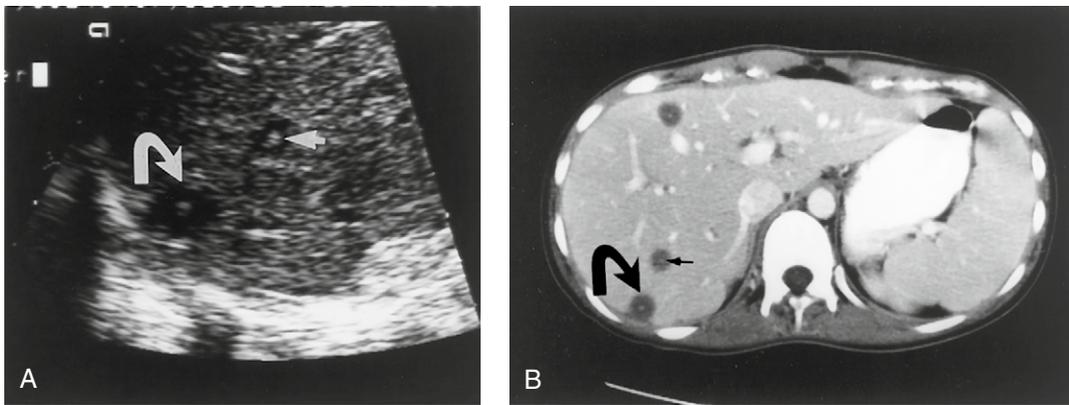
Aspergillus* liver abscesses in a young woman with leukemia who presented with abnormal liver function tests and fever. (A) Abdominal sonogram transverse scan through the liver shows hypoechoic areas (curved arrow) with a central echogenic focus (small arrow). (B) CT image of the liver in the same patient shows multiple hypodensities (curved arrow) with central hyperdensities (small arrow). The hyperdensity frequently consists of fungal organisms and necrotic tissue.
